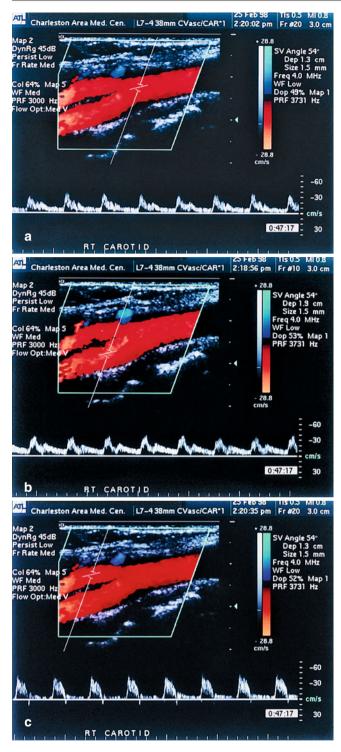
(a) A color duplex ultrasound image showing a normal common carotid artery with a normal Doppler spectra (*bottom of figure*). (b) A color duplex ultrasound image of the carotid bifurcation showing a normal internal carotid artery with a normal Doppler spectra (*bottom of figure*). (c) A color duplex ultrasound image of the carotid bifurcation showing a normal external carotid artery with a normal Doppler spectra (*bottom of figure*). (c) A color duplex ultrasound image of the carotid bifurcation showing a normal external carotid artery with a normal Doppler spectra (*bottom of figure*).
